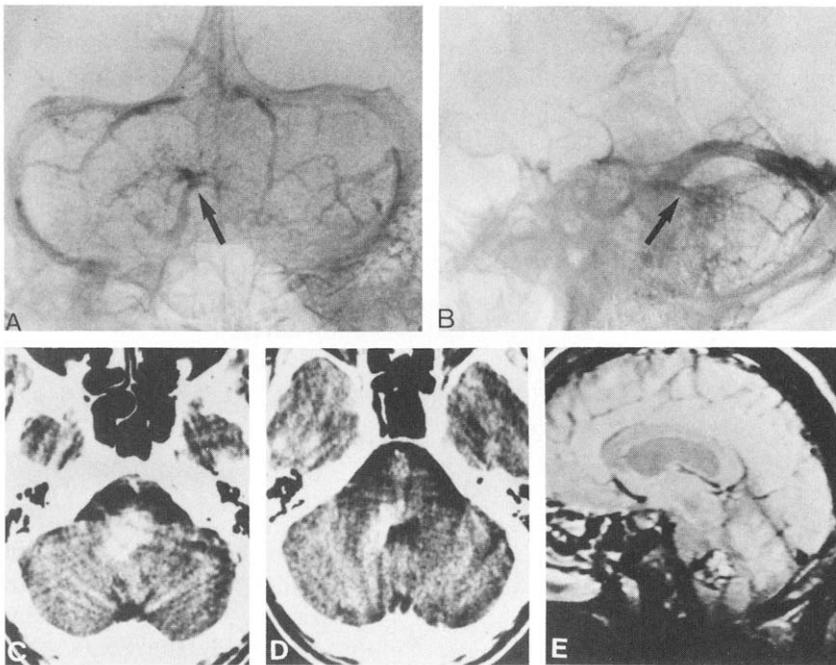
Case 1. (A) Anteroposterior and (B) lateral views of the right vertebral angiograms in the venous phase demonstrate multiple spokelike venous structures (arrows) in the right cerebellar hemisphere that drain into a dilated petrosal vein. (C) A CT scan with contrast shows an enhancing, irregularly defined abnormality in the pons and right middle cerebellar peduncle. (D) There is prominence of vein posterior and superior to the lesion. (E) An MRI demonstrates an area of signal abnormality with little mass effect in the pontine tegmentum and right brachium pontis.
